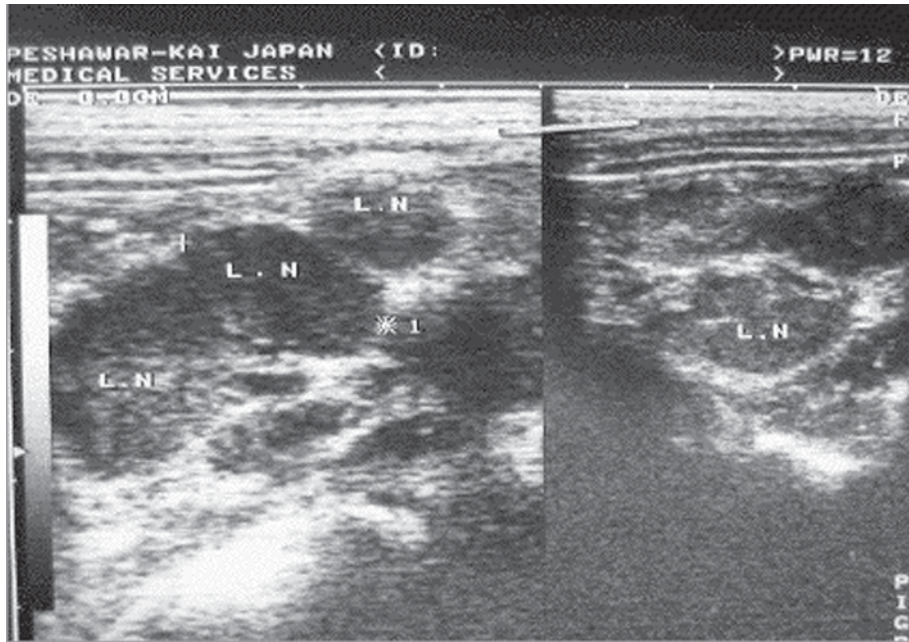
Ultrasonographic image of the culture-confirmed 6-year-old female case. Multiple enlarged lymph nodes were seen in the right lower quadrant area. One of the largest measured 1.6 cm.
